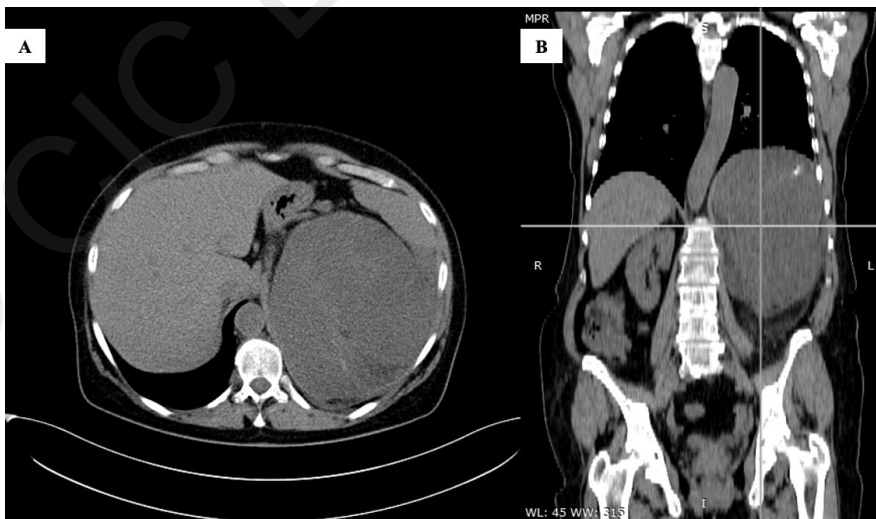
Contrast enhanced computed tomography (CT) findings for a retroperitoneal sarcoma. A) Cross section; B) Coronal section.
